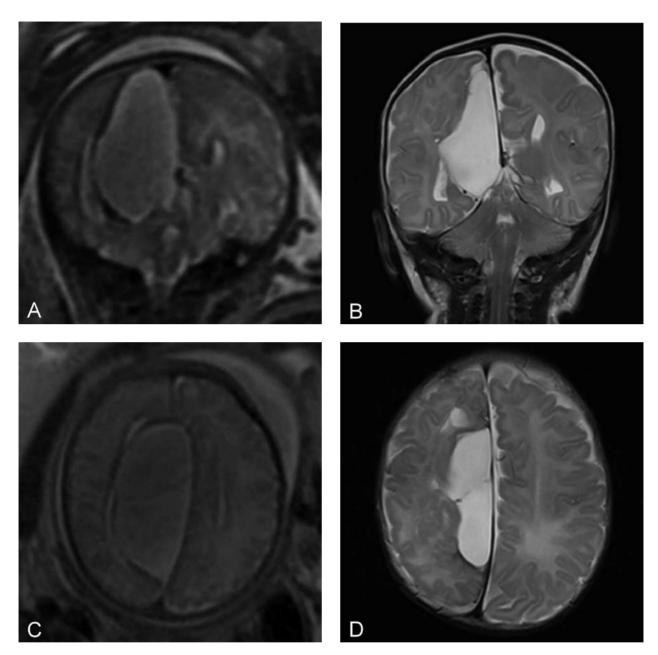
A and C: Prenatal coronal and axial magnetic resonance images revealing a large multiloculated interhemispheric cyst; B and D: follow-up coronal and axial magnetic resonance images acquired 1 month after cystoventriculocisternostomy revealing reduction in cyst volume and expansion of brain parenchyma.
